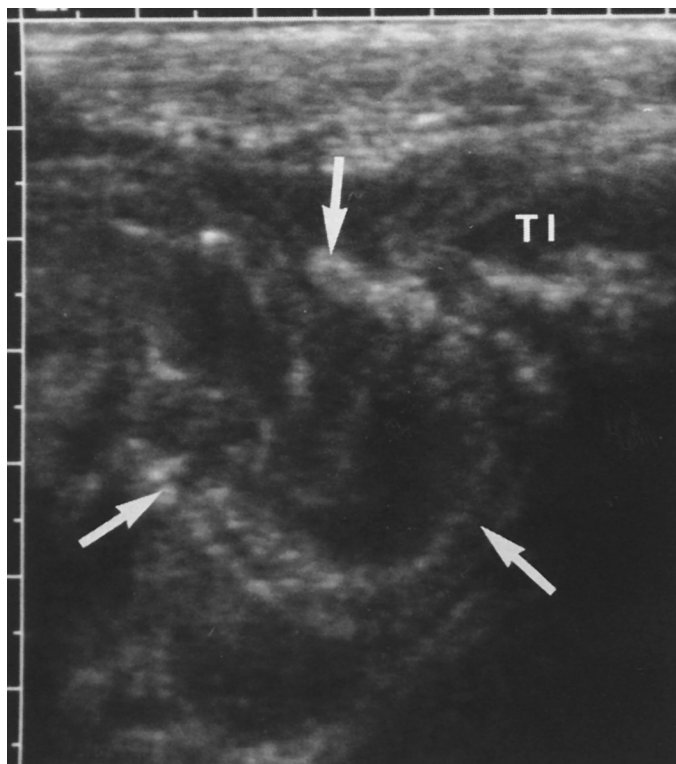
An ultrasound scan of the right lower quadrant in a 6-year-old girl, demonstrating a thick-walled cecum (arrows) outlined by echogenic fluid. No appendix was found in spite of careful ultrasonographic searching. During surgery, the patient was found to have a perforated appendix and early periappendiceal abscess. TI, terminal ileum. (From Teele R, Share J. Appendicitis and other causes of intraabdominal inflammation. In: *Ultrasonography of Infants and Children*. Philadelphia: WB Saunders; 1991.)
